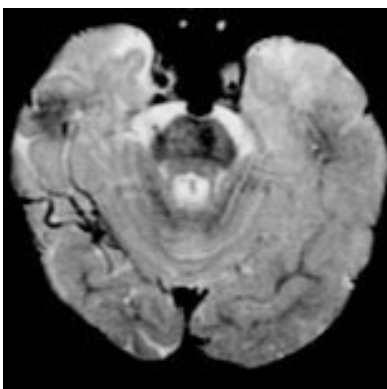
T2 weighted magnetic resonance image (axial section) showing a high intensity rim around the left internal carotid artery which has a smaller lumen than the contralateral vessel. The rim represents the intramural haematoma which has resulted from dissection of the vessel.
